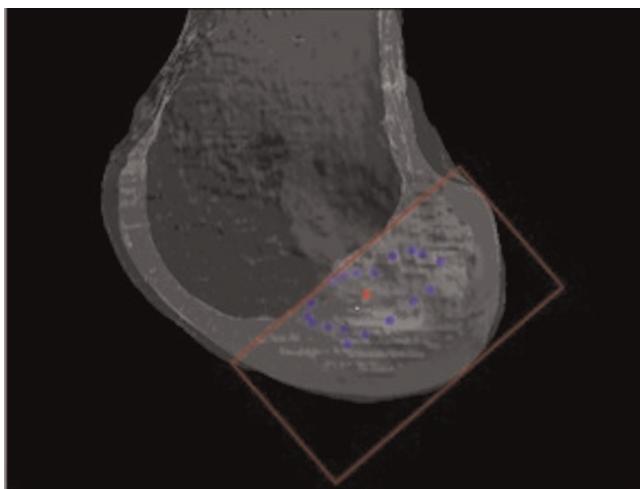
Three-dimensional computed tomography bone model with the digitized femoral posterior cruciate ligament insertion site co-registered.
